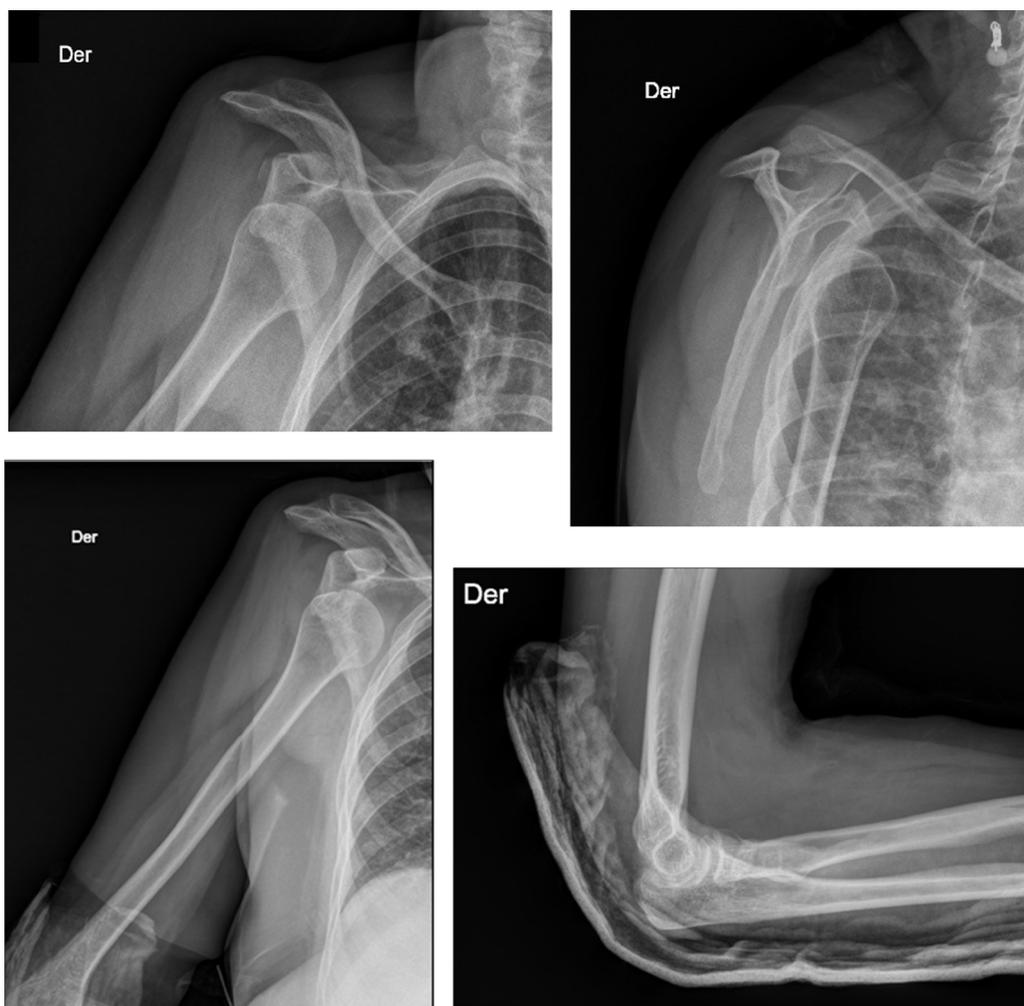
Right shoulder x-ray projections showing an anteroinferior shoulder dislocation. Lateral x-ray of the right elbow showing satisfactory reduction.
